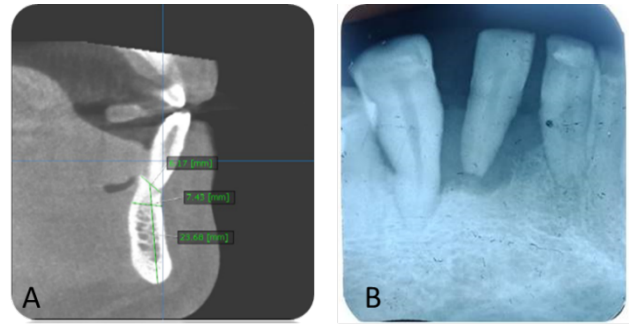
a) preoperative CBCT, b) IOPAR evaluation
